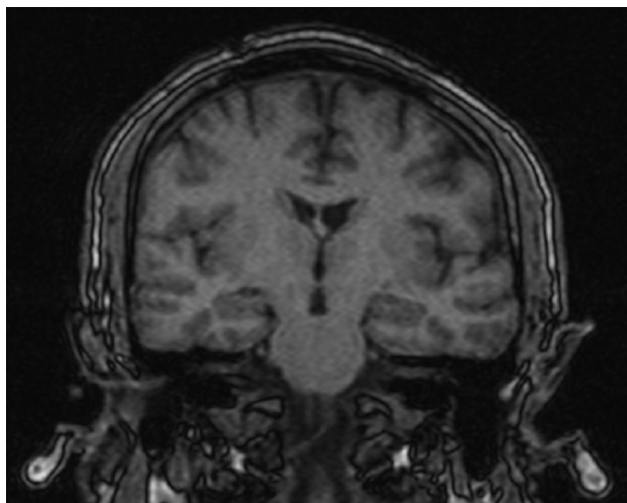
T1 weighted brain MRI scan
